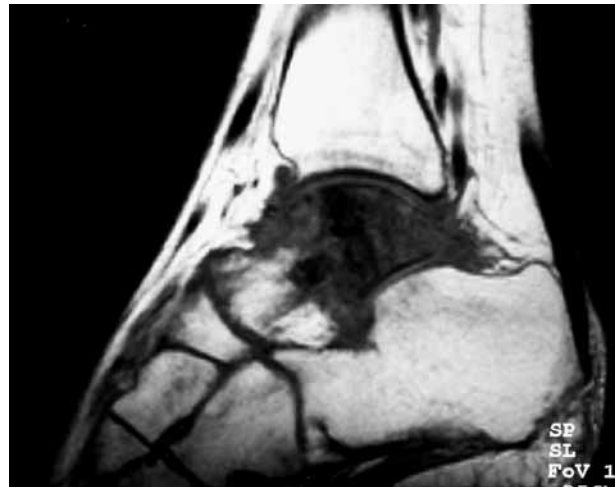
MRI showing the tumoral lesion in the talus with extraosseous invasion.
